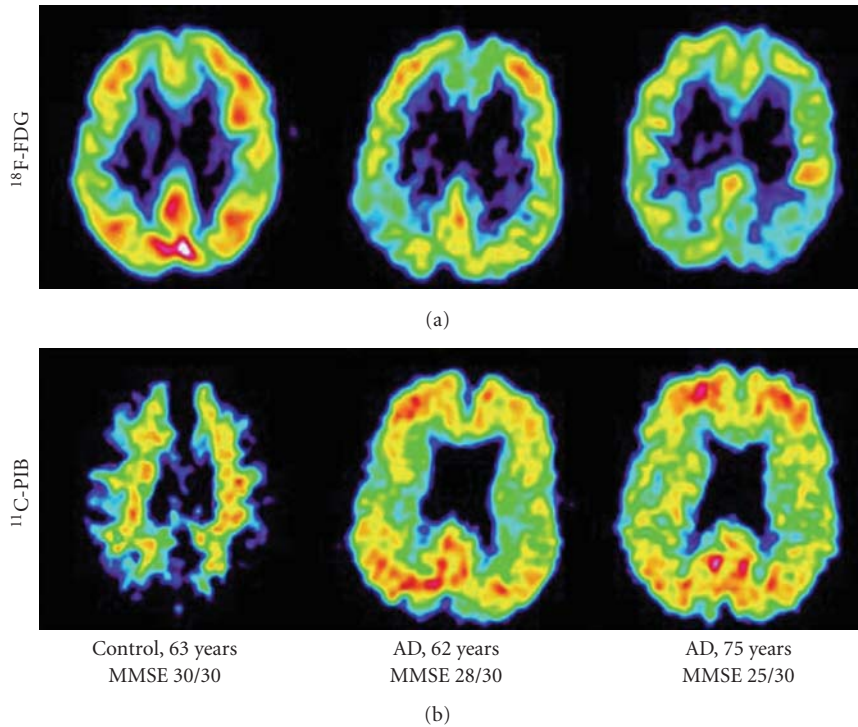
Cerebral glucose metabolism (^{18}F -FDG) and ^{11}C -PIB amyloid imaging in two AD patients and one healthy control. The PET scans show ^{18}F -FDG and ^{11}C -PIB at a sagittal section. MMSE: Mini Mental State Examination. Adapted from [43].
